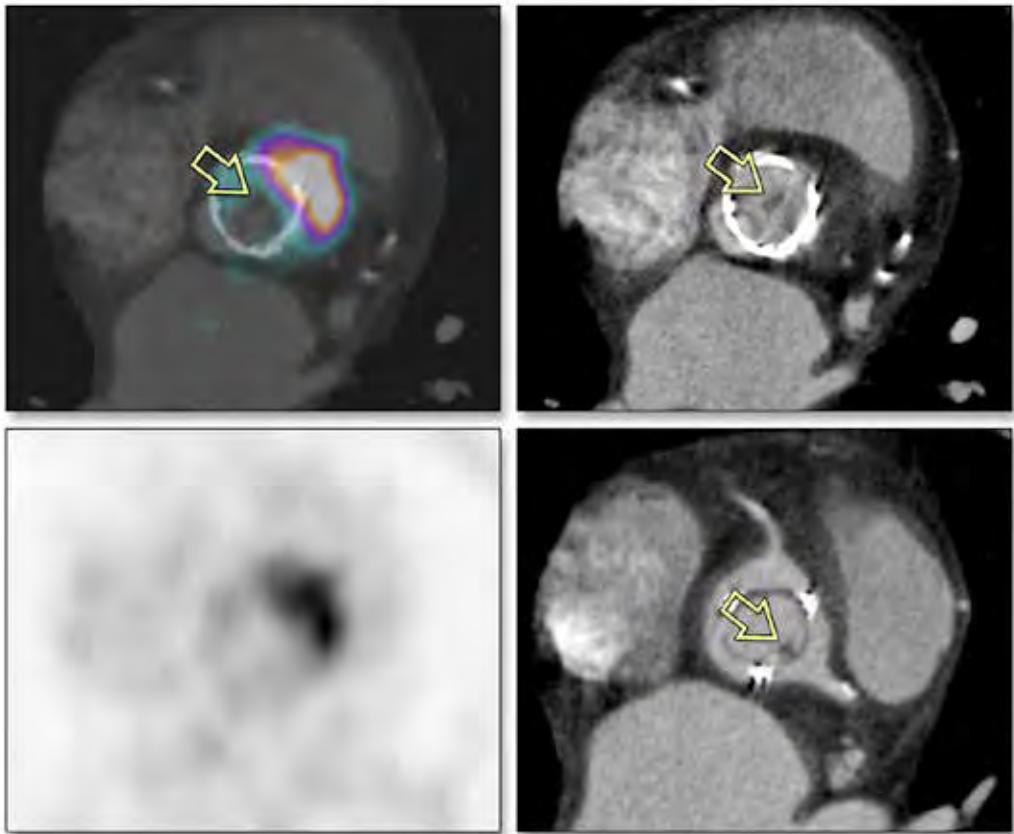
False-negative ^{18}F -FDG PET/CT in valve vegetation. ^{18}F -FDG PET/CT is not capable of excluding vegetations on PHV, as they are likely to be false negatives. PET shows pathological hyperactivity in the aortic wall, but not in the vegetation (arrows) visible on CT angiography (diastolic phase upper right, systolic phase lower right). Several factors may contribute to low levels of activity in vegetations, from the limited spatial resolution of ^{18}F -FDG PET/CT to a lesser cellular component in the inflammatory response to vegetations. ^{18}F -FDG PET/CT should always be combined with echocardiography or CT angiography of the valve to rule out solitary vegetations.
